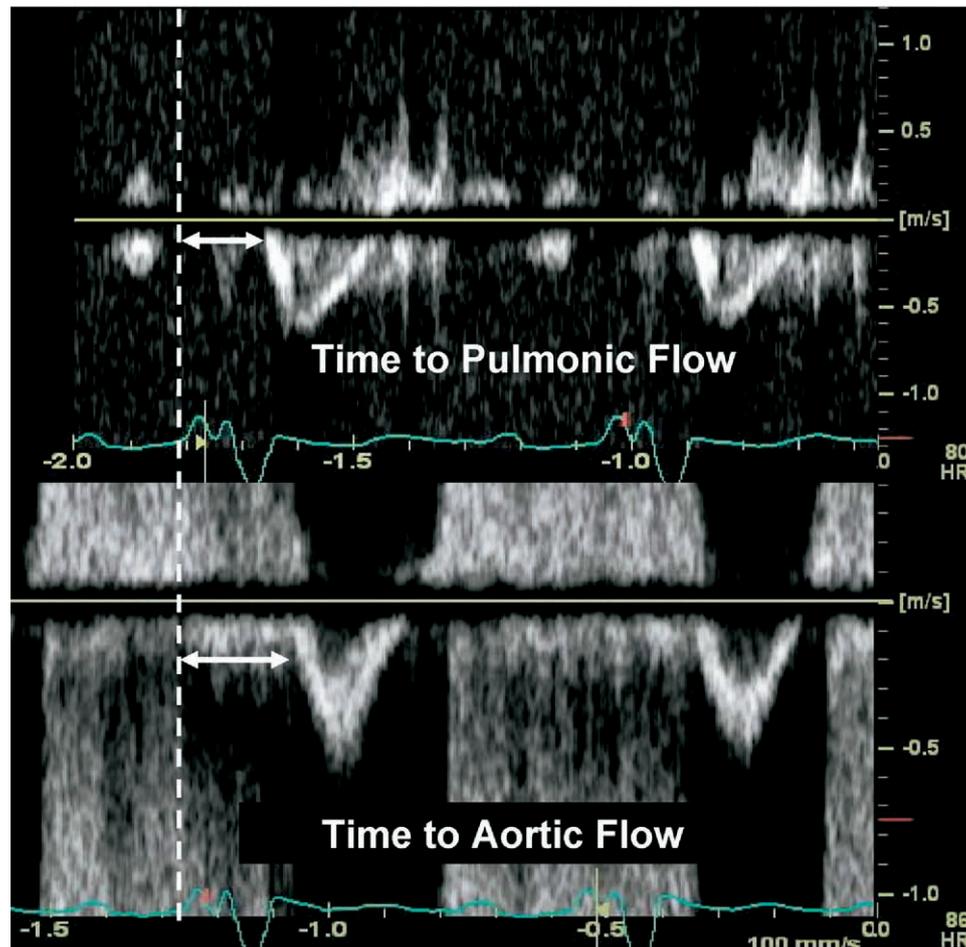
Pulsed Doppler from right ventricular outflow tract and left ventricular (LV) outflow tract demonstrating significant delay in LV ejection (>40 milliseconds).
